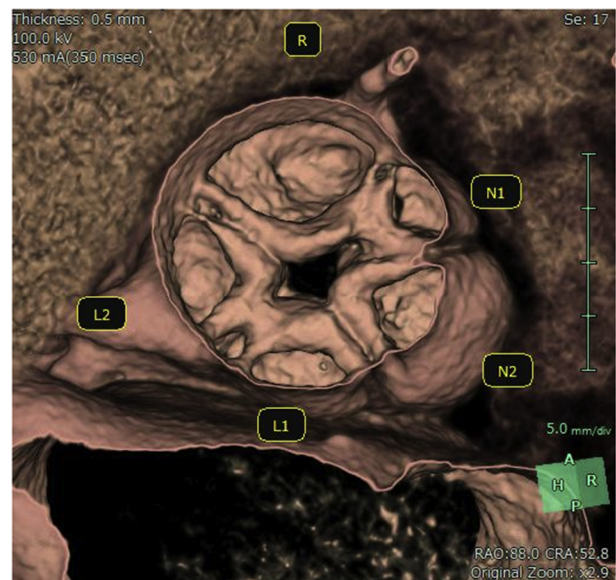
Preoperative computed tomography. Aortic valve consisted of 5 leaflets: 2 small left coronary cusps, 2 small noncoronary cusps, and 1 relatively large right coronary cusp. L1/L2, Left coronary cusp 1 or 2; N1/N2, noncoronary cusp 1 or 2; R, right coronary cusp.
